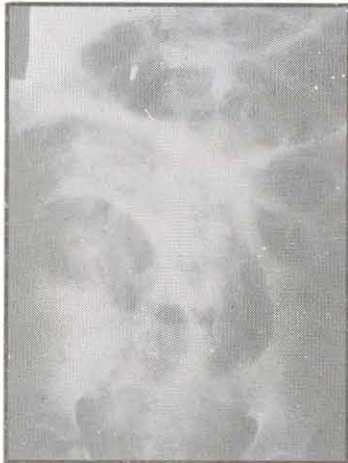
Plain X-ray abdomen showing a segment of the dilated small intestines packed with round worms fairly well contrasted against gas in intestines.
